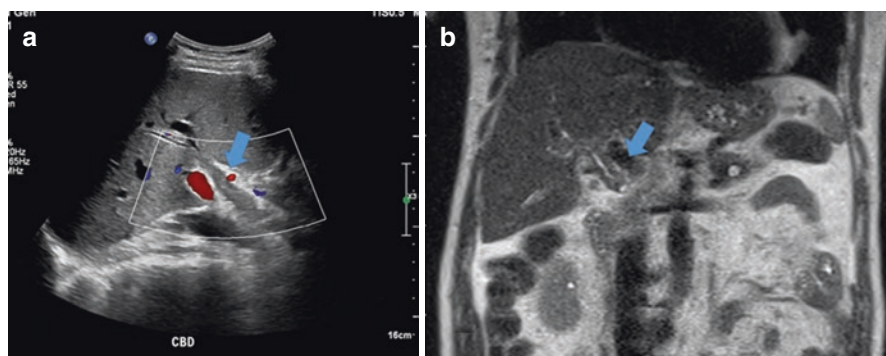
Extrahepatic combined perihilar/distal cholangiocarcinoma (combined pCCA/dCCA) with periductal infiltrating growth pattern. Color Doppler abdominal ultrasound (a) demonstrates thickened common bile duct with tumor (blue arrow). Coronal T2-weighted MR (b) demonstrates long segment thickening of the common bile duct in a periductal infiltrating pattern (blue arrow)
